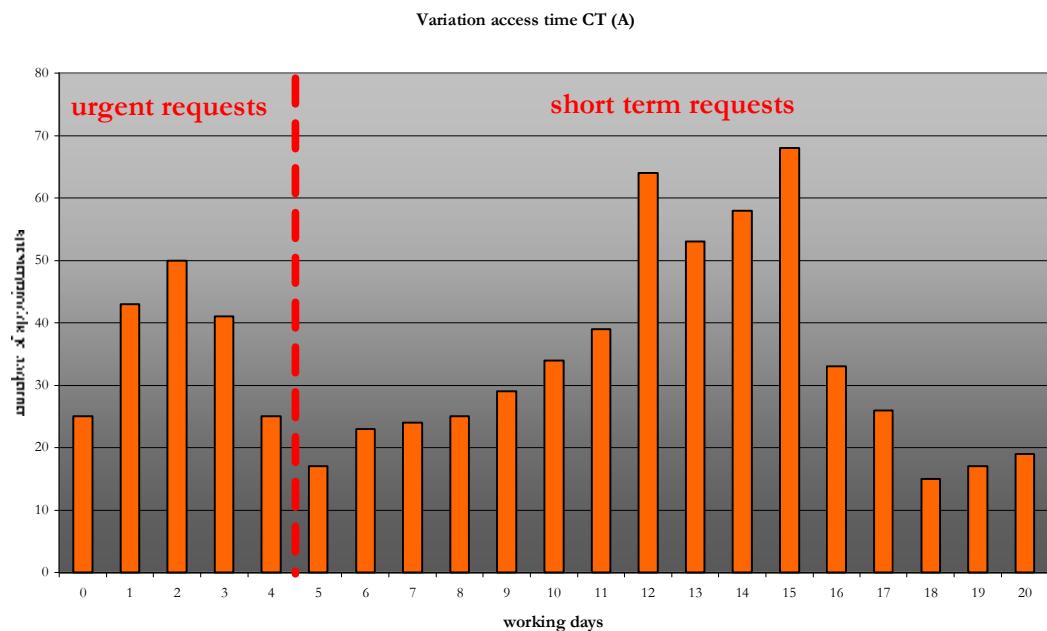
Variation in access time CT scanner (Data CT: 07-10-2007 – 31-03-2008)
